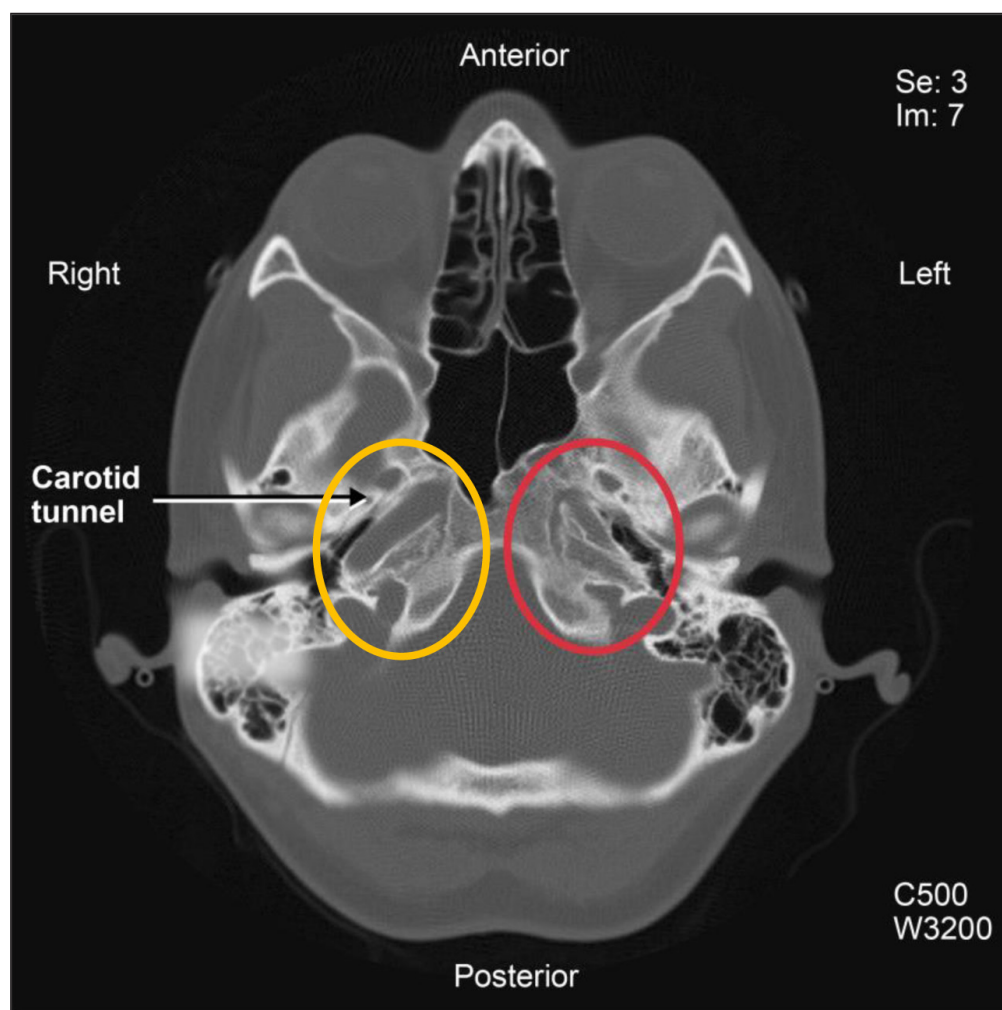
Computed tomography demonstrating absent carotid canal at the base of the skull on the left.
